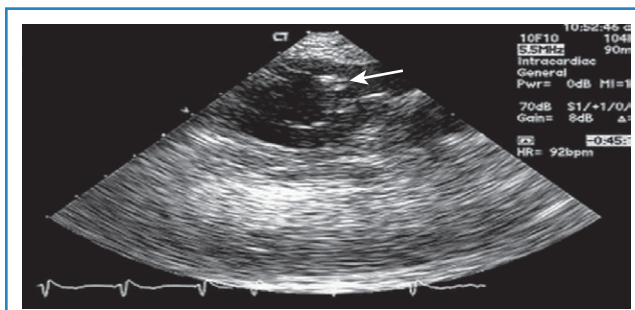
Intracardiac echocardiography image of a circular mapping catheter within the left atrium. A mobile echodensity is demonstrated on the catheter (arrow).
